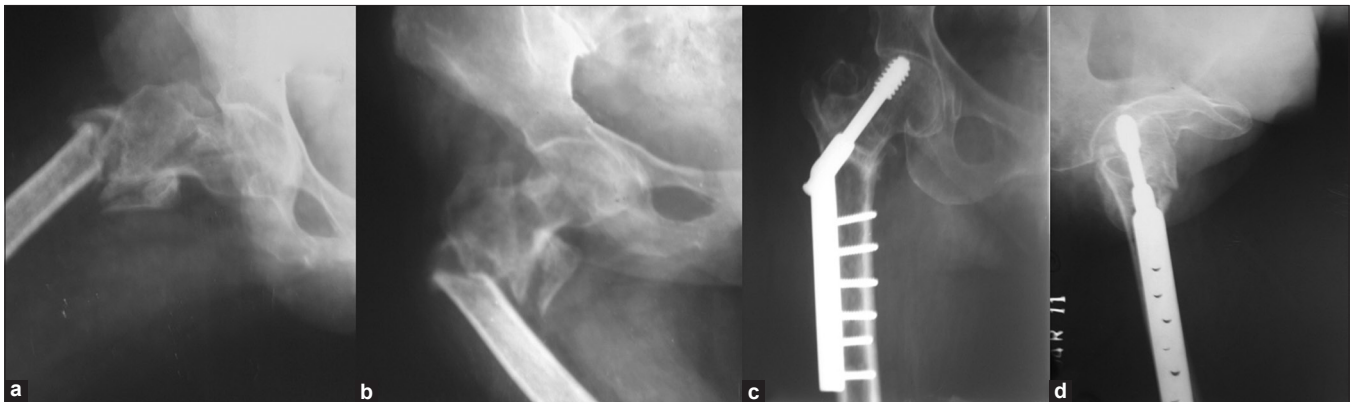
Abduction–adduction anteroposterior X-rays (a and b) showing hypermobile nonunion in a 62-year-old female (c and d) X-rays anteroposterior and lateral views at 6 months showing union
